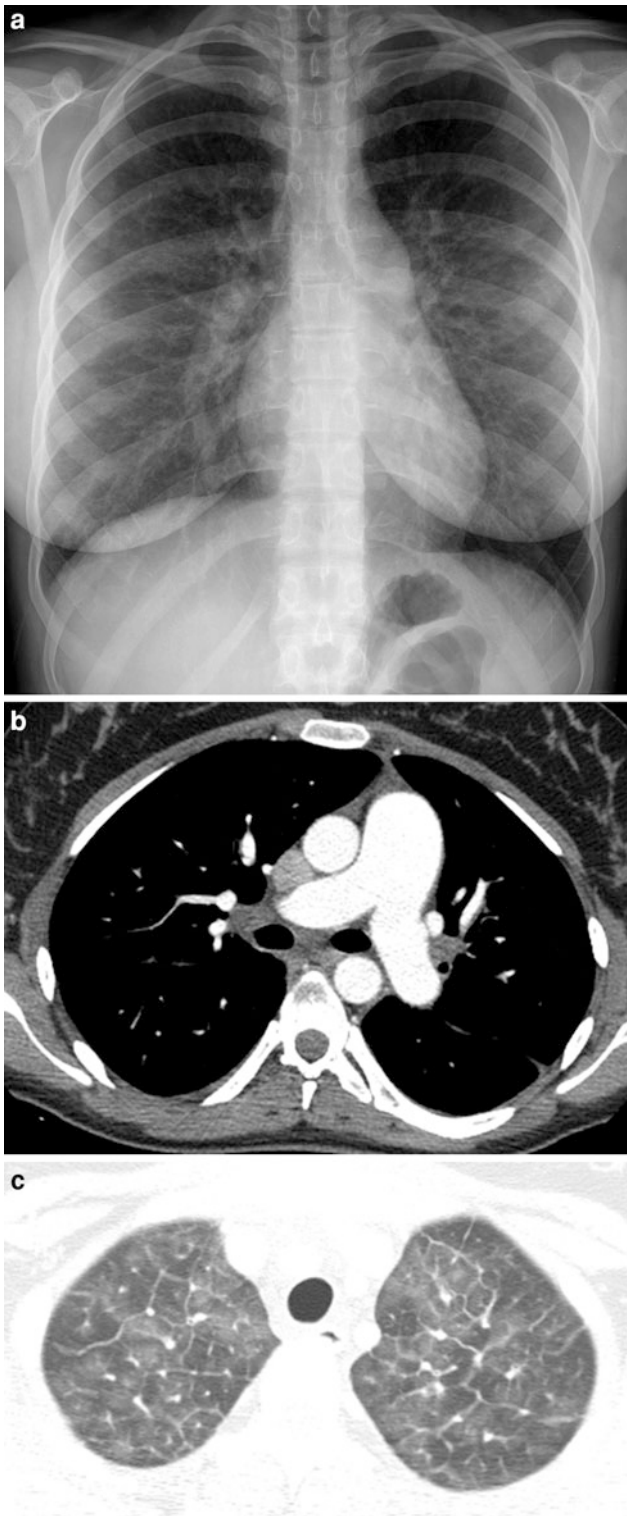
Pulmonary veno-occlusive disease. A frontal CXR (a) of an 18-year-old with progressive dyspnea on exertion shows main pulmonary enlargement and subtle Kerley B lines at the lateral lung bases. Axial chest CT images (b, c) confirm the presence of pulmonary artery enlargement and interlobular septal thickening, and reveal mild hilar lymph node enlargement and a tiny pleural effusion
